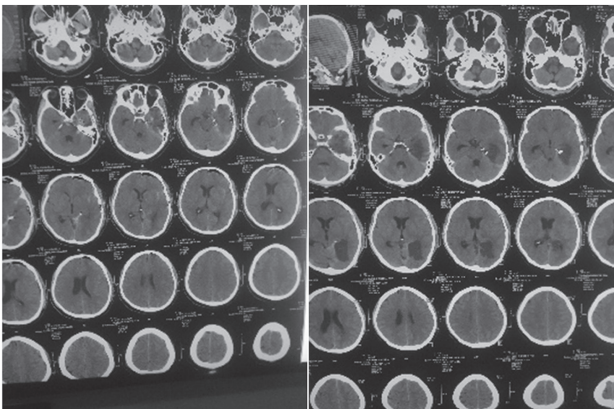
CT Scan of first postoperative day showing no hematoma and infraction except mild edema and residual SAH
